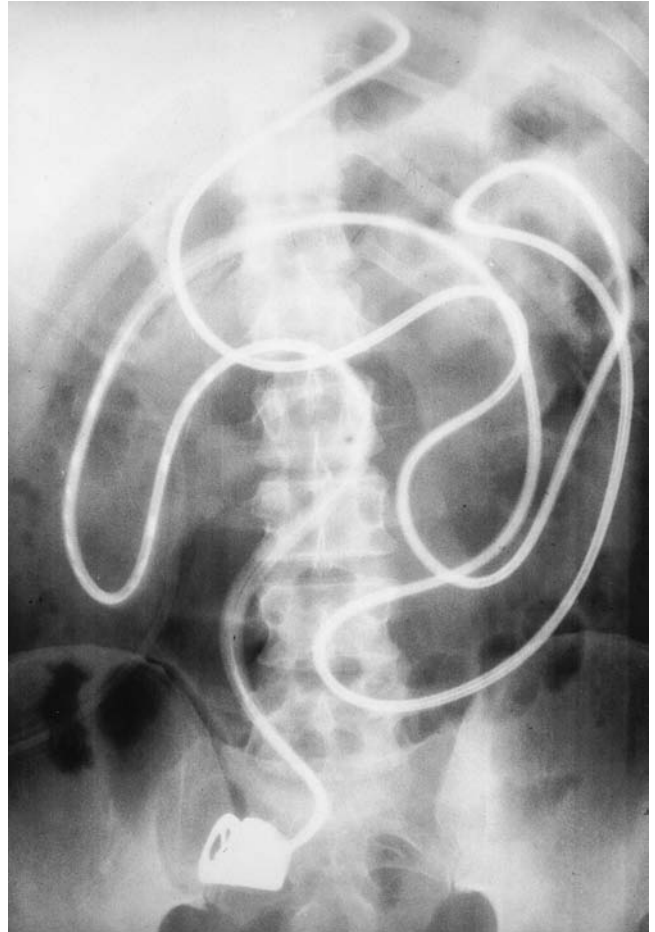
Abdominal radiograph showing distal passage of a long nasointestinal decompression tube into the small bowel distal to the ligament of Treitz.
